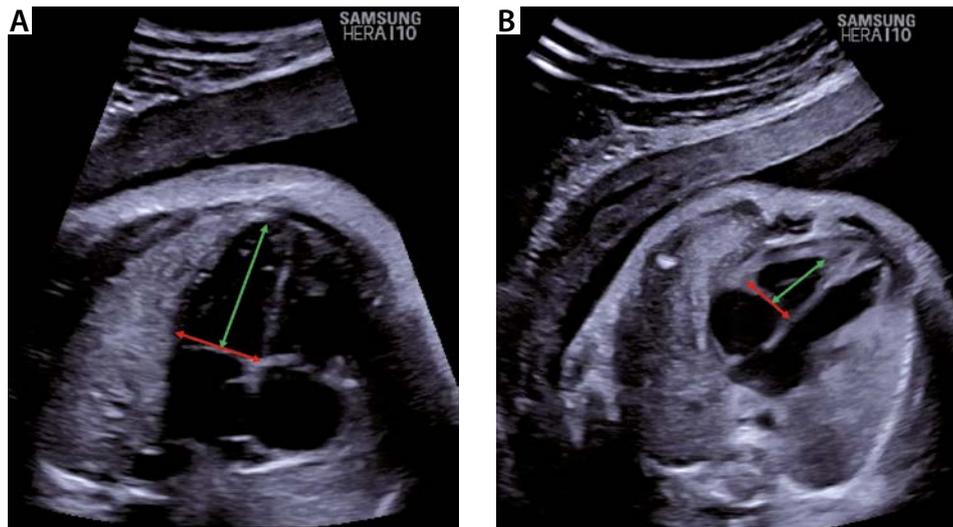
Echocardiographic images of two fetuses at 30 weeks of gestation from an uncomplicated pregnancy (A) and poorly controlled GDM (B). Right ventricle sphericity index (SI) was 1.46 and 1.19, respectively. For the computation of SI, the end-diastolic mid-basal-apical length (green arrows) is divided by the basal transverse length (red arrows)
